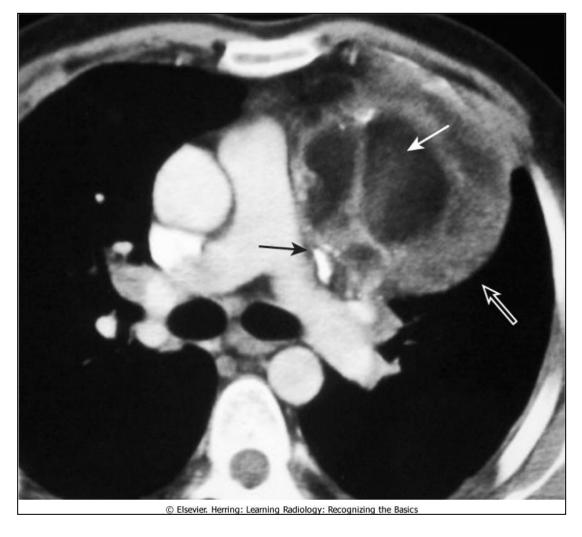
Mediastinal teratoma. Teratomas are germinal tumors that typically contain all three germ layers. They tend to be discovered at a younger age than thymomas. The most common variety of teratoma is cystic (closed white arrow), as in this case. As shown here, they usually produce a well-marginated mass (open white arrow) near the origin of the great vessels. They characteristically contain fat, cartilage, and sometimes bone (closed black arrow) on CT.
